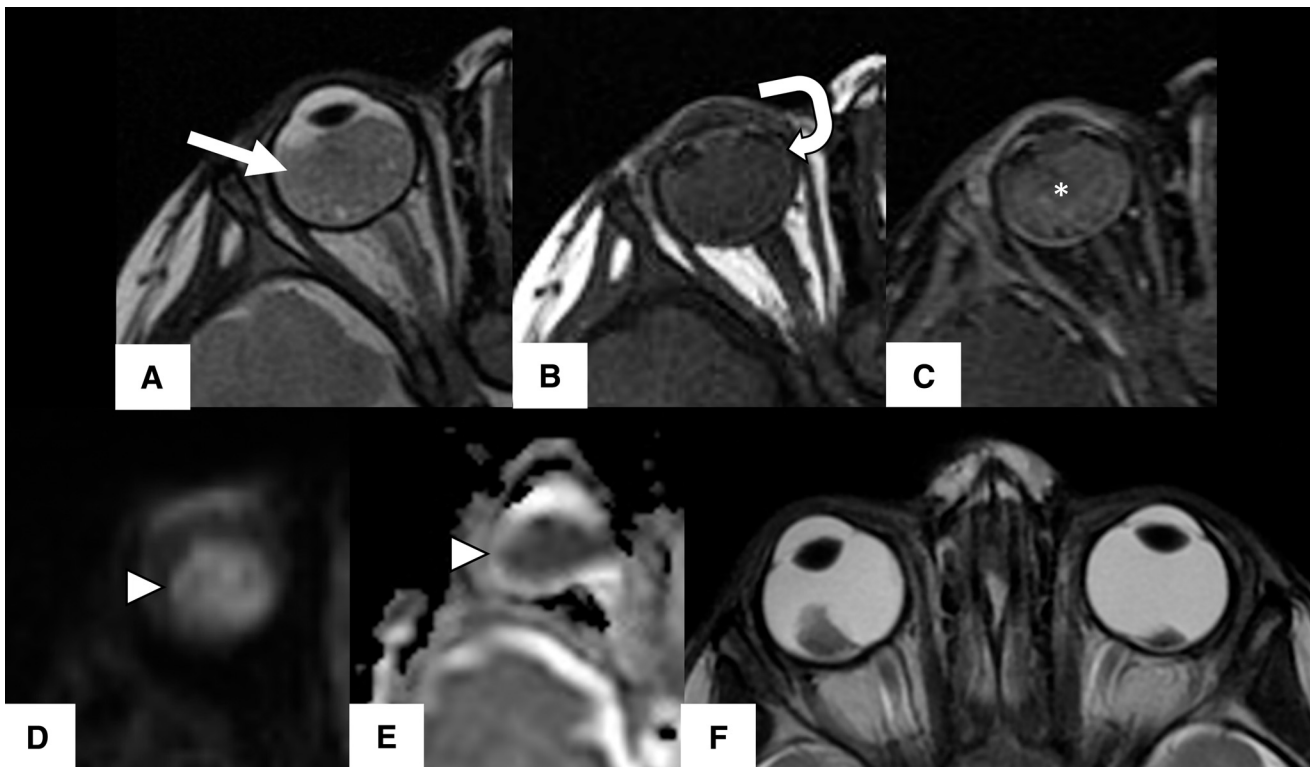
Retinoblastoma of the right eye. Orbital MR imaging. Axial T2-weighted (A), T1-weighted (B), postcontrast T1 (C), DWI (D), and an ADC map (E) show classic findings of retinoblastoma, including a T2-hypointense intraocular mass (white arrow) that is isointense on T1 (curved arrow) and shows contrast enhancement (asterisk) and diffusion restriction (arrowheads). An axial T2-weighted sequence (F) in a different patient shows bilateral retinoblastomas.
